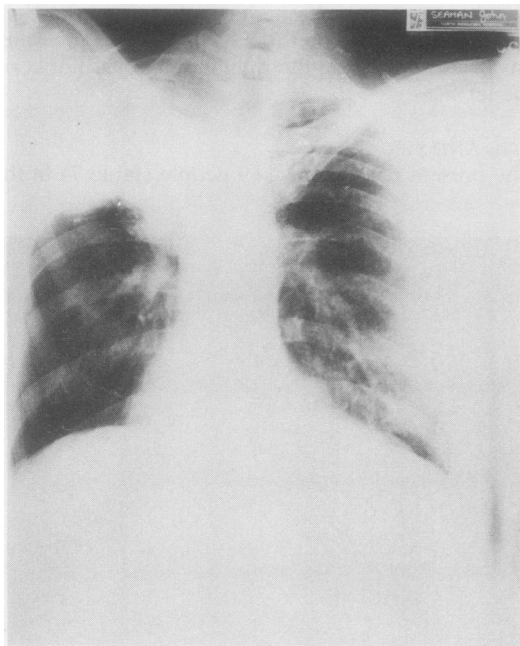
Thirty one years after a right drilled polythene sphere plombage—the type of plombage cannot be identified radiographically.*
